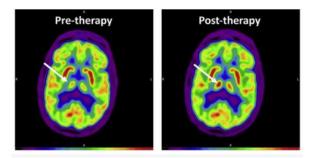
tDCS FDG-PET transaxial image acquired pre- and post-tDCS therapy [10]
